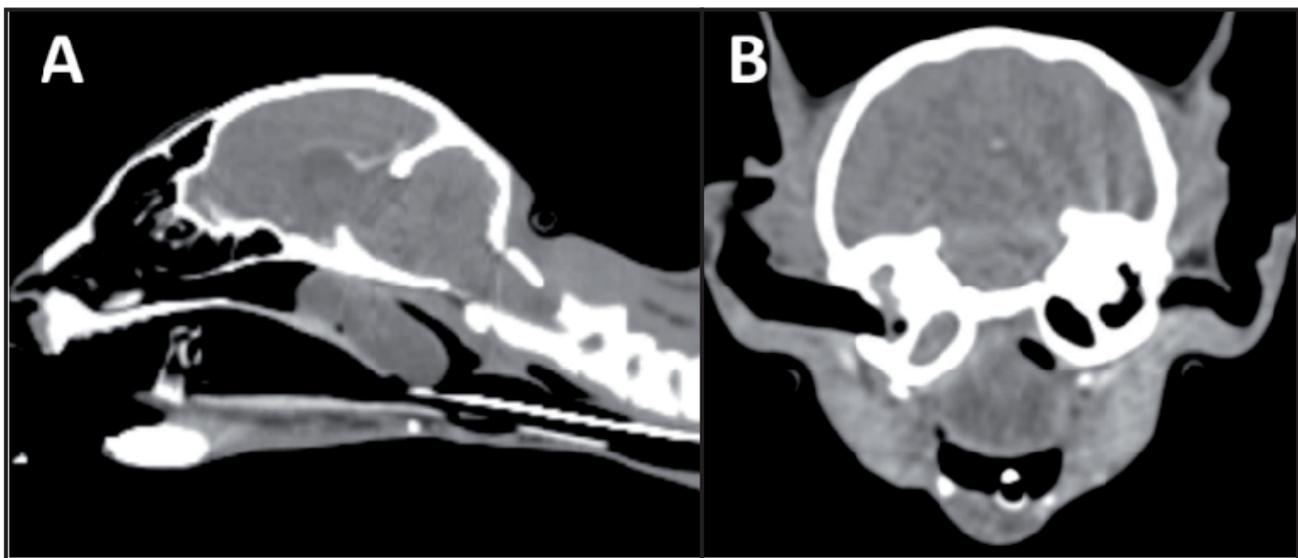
Postcontrast CT image. A- A space-occupying mass adjacent to the soft palate in the nasopharynx was observed on the sagittal plane. B- A soft tissue density in the right tympanic bulla was observed on the transverse plane.
